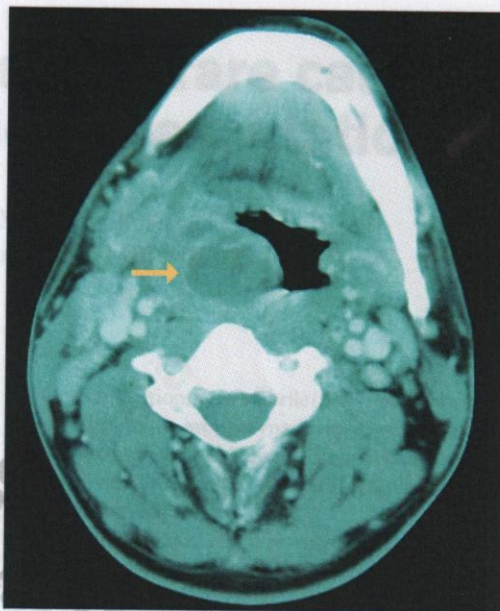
CT of the neck shows the 2.6 × 2.3-cm intratonsillar abscess (arrow).
